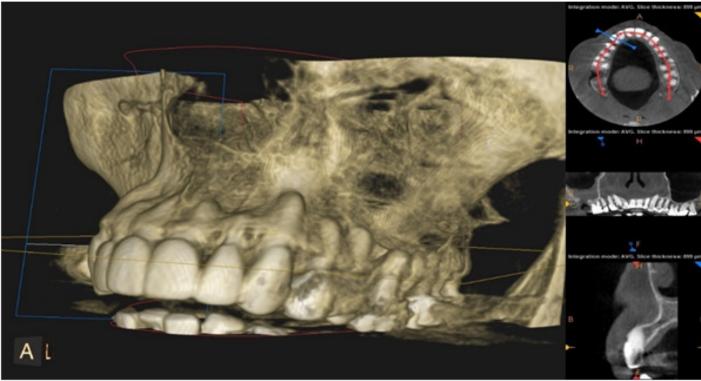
CBCT showing the thin bone biotype in maxilla jaw bone
